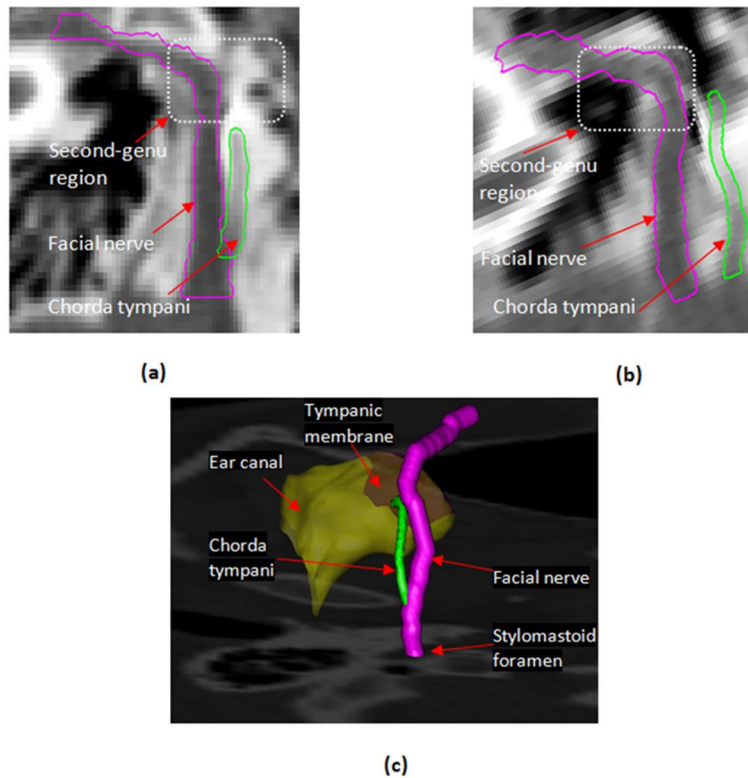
Comparison of facial nerve and chorda tympani structures in an adult and a pediatric CT scans. (a) Contours of facial nerve and chorda tympani in an adult CT. (b) Contours of facial nerve and chorda tympani in a pediatric CT. (c) 3D rendering of the anatomy
